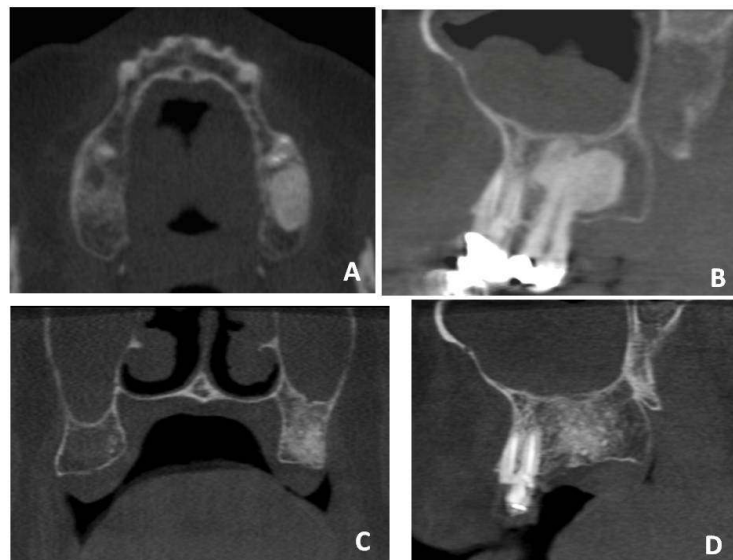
(A) Axial and (B) sagittal slice images from cone beam CT. (C) Coronal and (D) sagittal images performed during follow-up showing no signs of recurrence
